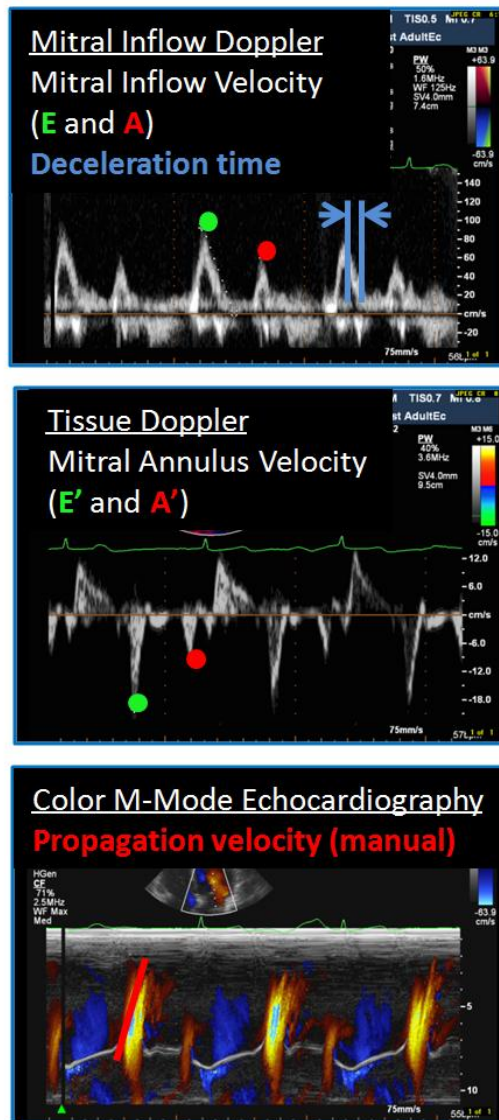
Conventional diagnostic parameters. Top shows a mitral inflow Doppler, measuring the velocity of blood crossing the mitral valve. Peak E velocity (green dot) and peak A velocity (red dot) are used to diagnose LVDD. The deceleration time, indicated by the two blue lines is related to LV relaxation. Middle shows tissue Doppler measuring the mitral annular velocity. E' and A' are indicated by the green and red dots. Bottom shows CMM echocardiography which records a line scan of centerline blood velocity from the mitral valve to the apex. These “waves” are used to evaluate filling or manually measure a propagation velocity (red line).
